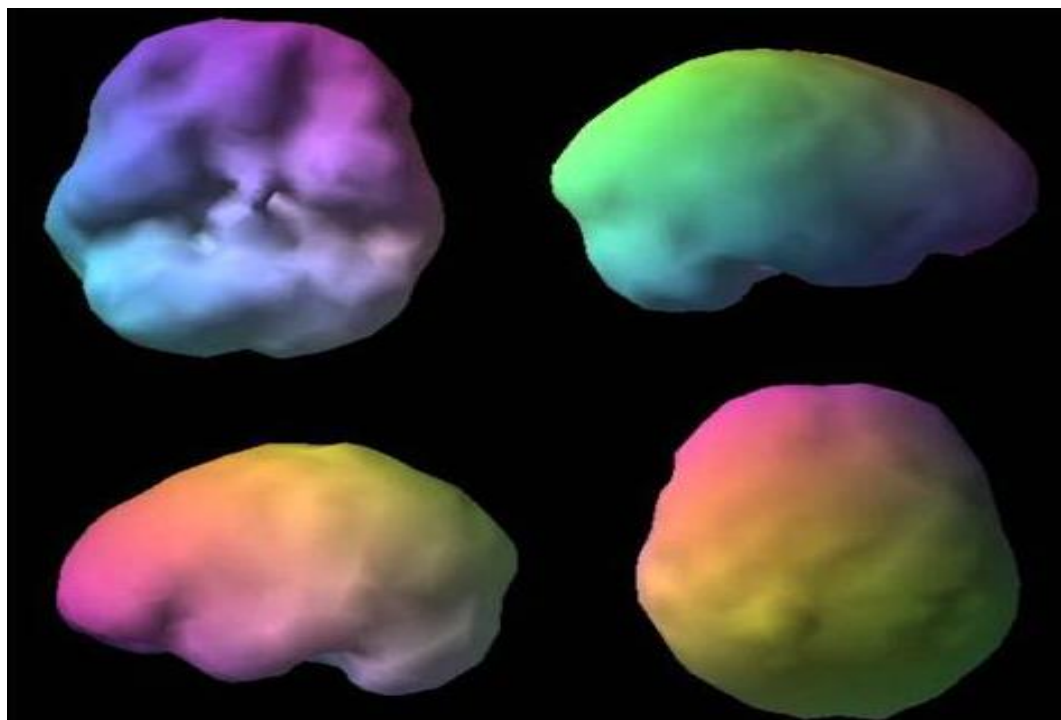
Shows a good 3dimensional surface depiction of SPECT data, with the top forty-five percent of brain perfusion shown as a hole or a dent, and whatever thing beneath that level as a whole or a depression. The holes do not indicate a lack of perfusion; rather, they indicate a low level of perfusion as compared to a healthy database. 3 standard deviations under normal indicate activity underneath the top forty-fifth percentile. Perfusion is complete, even, and symmetrical in a healthy scan [19].
